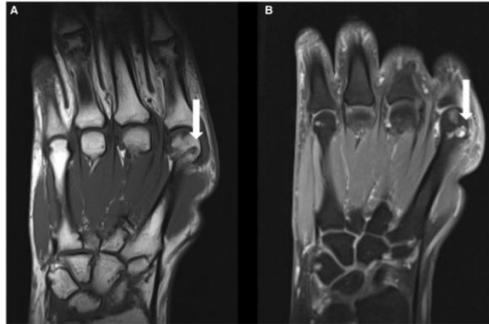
Coronal MRI MCP joint images of an SLE patient
